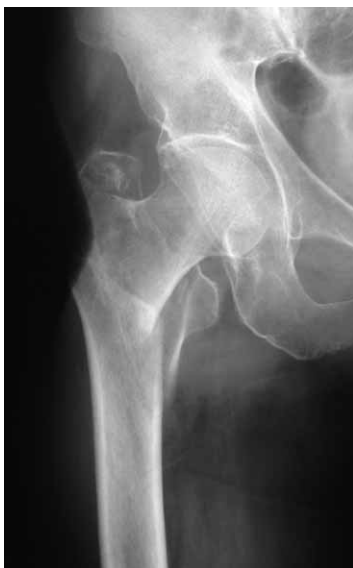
Preoperative AP radiograph of the hip shows unstable trochanteric femoral fracture with grade I osteoarthritis of the hip according to Kellgren-Lawrence grading scale.
